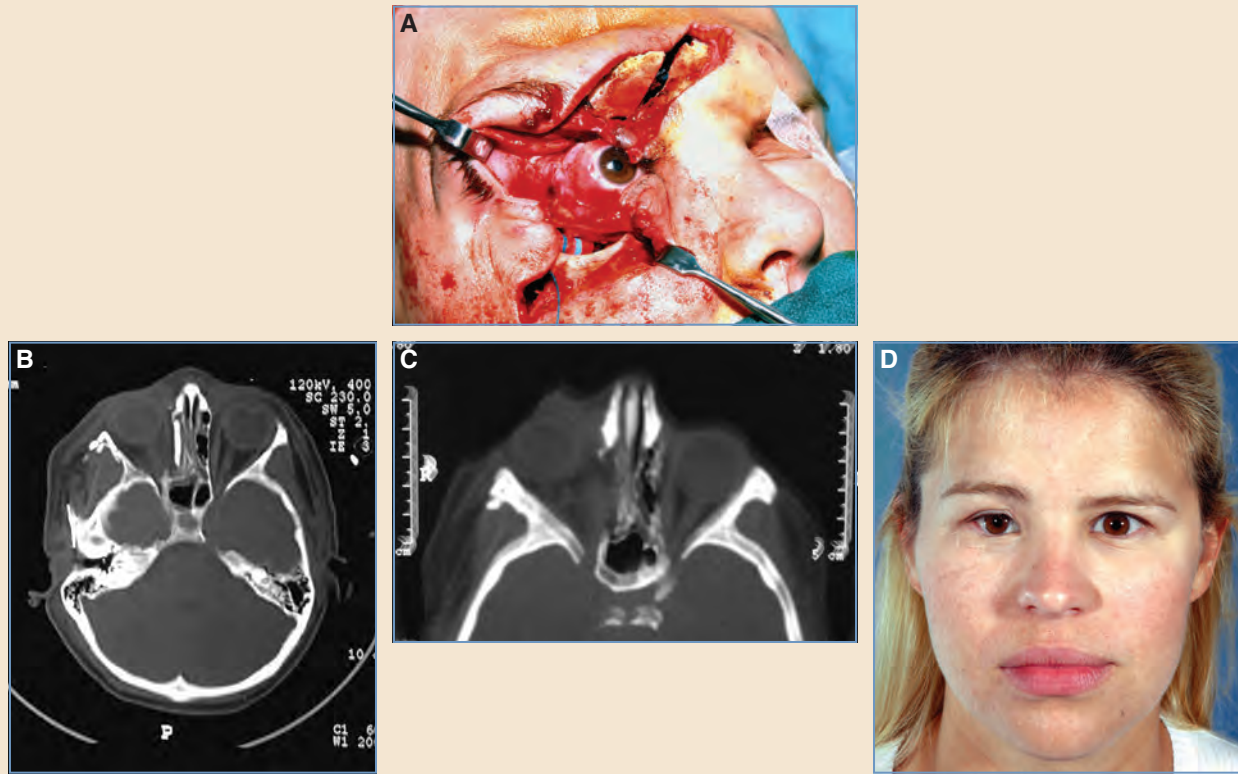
This young girl was run over by a motorboat propeller. A, Her upper and lower eyelids were lacerated and partially avulsed, and the propeller passed through the anterior cranial base. The globe was preserved. B and C, Two axial CT views show the associated orbital wall injuries. D, The patient is shown postoperatively after reduction and fixation of the zygomatic fracture; cranial bone grafts to the orbital roof, medial wall, and floor; and meticulous repair of the eyelid injuries. The medial rectus muscle was mildly damaged. The patient may require an adjustment of the medial and lateral rectus muscle insertions. (Courtesy of S. Anthony Wolfe, MD.)
